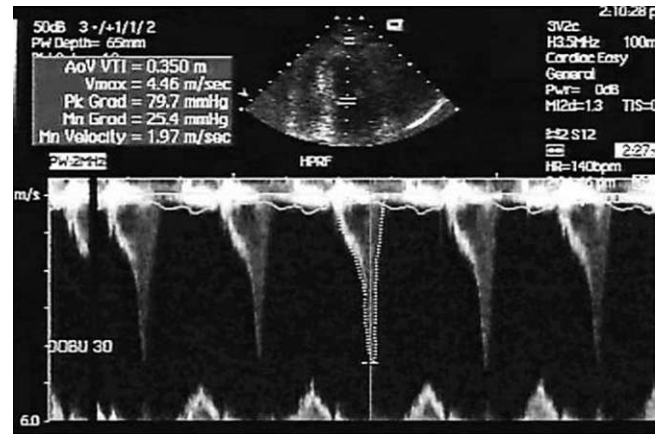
Example of a high-pulsed repetition Doppler flow velocity recording in the left ventricular outflow tract. Abnormal intraventricular flow velocities were defined as a dagger-shaped Doppler spectrum ≥ 3 m/s.
